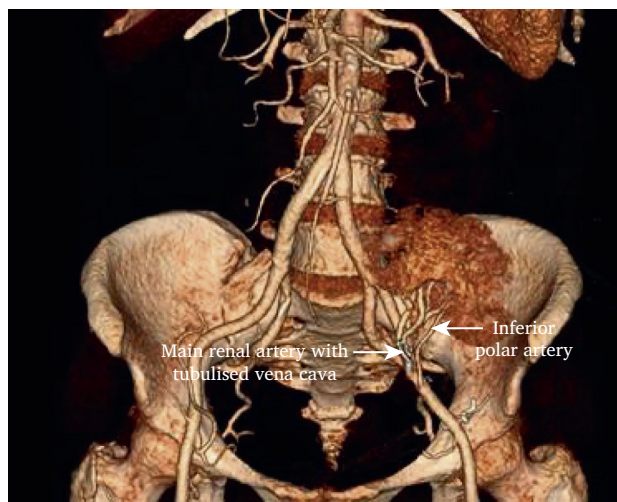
Computed tomography angiography reconstruction.
